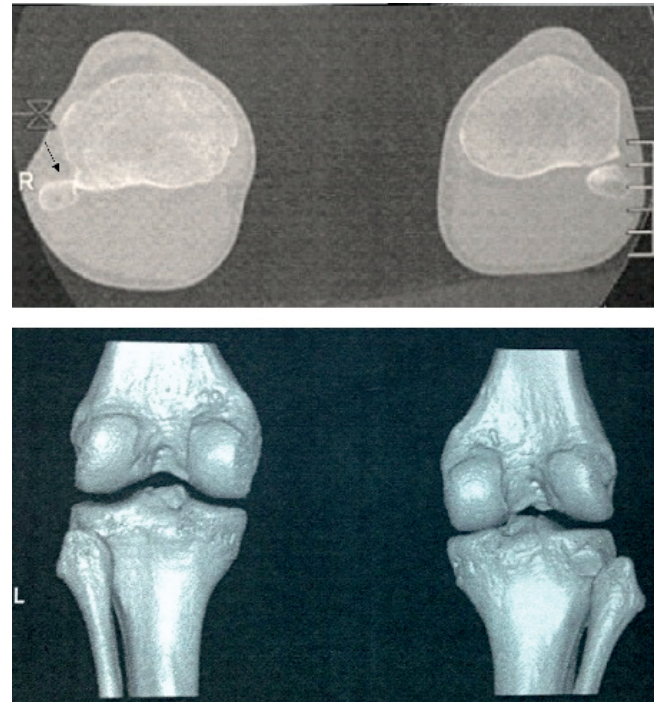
Comparative axial CT scan images, clearly identified a right anterolateral proximal tibiofibular joint dislocation.
